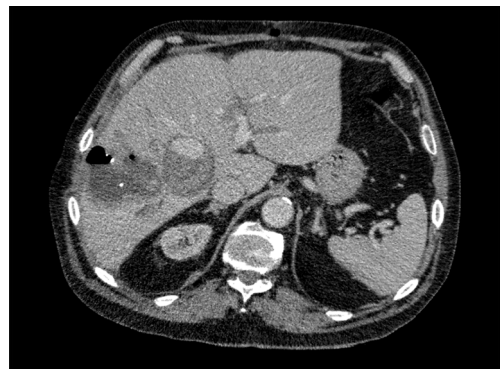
Contrast-enhanced computed tomography showed a collection with an air-fluid level and an hypervascular enhancing lesion.
